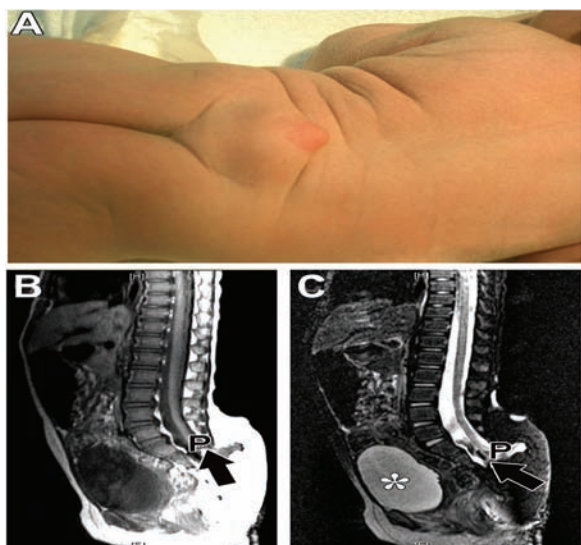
An image showing lipomyelomeningocele: A) a newborn with subcutaneous mass above the gluteal crease; B) sagittal T1-weighted MRI image (taken at the age of 26 months) shows large subcutaneous lipoma with fatty tissue extending through a wide posterior spina bifida into the spinal canal (arrow) to connect with the placode (P); C) sagittal T2-weighted MRI image (with fat saturation) showing the lipoma attached (arrow) to the placode (P). Note the distended urinary bladder (asterisk) with irregularity of the posterior wall suggesting the presence of neurogenic bladder.
